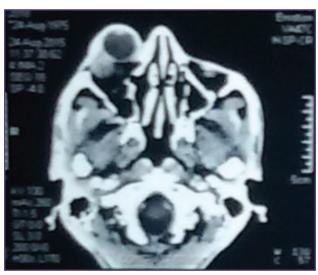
A CT scan of the right orbit showing lobulated heterogeneous enhancing solid space occupying lesion, arising from superolateral angle causing proptosis. No evidence of underlying bone erosion or cystic areas and intracranial extension is noted.
